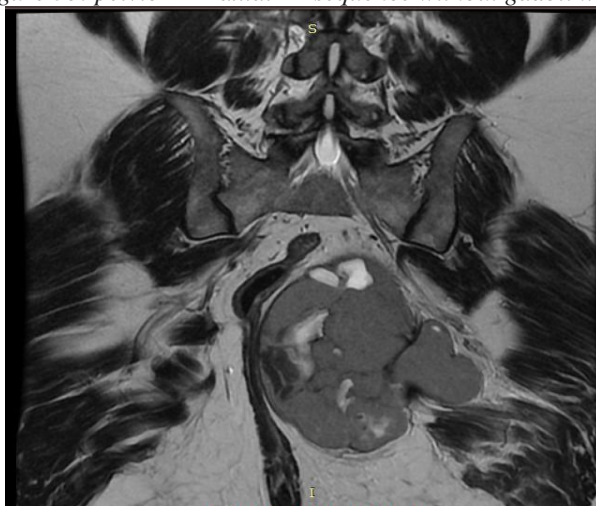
pelvic MRI coronal T2 sequence without gadolinium
